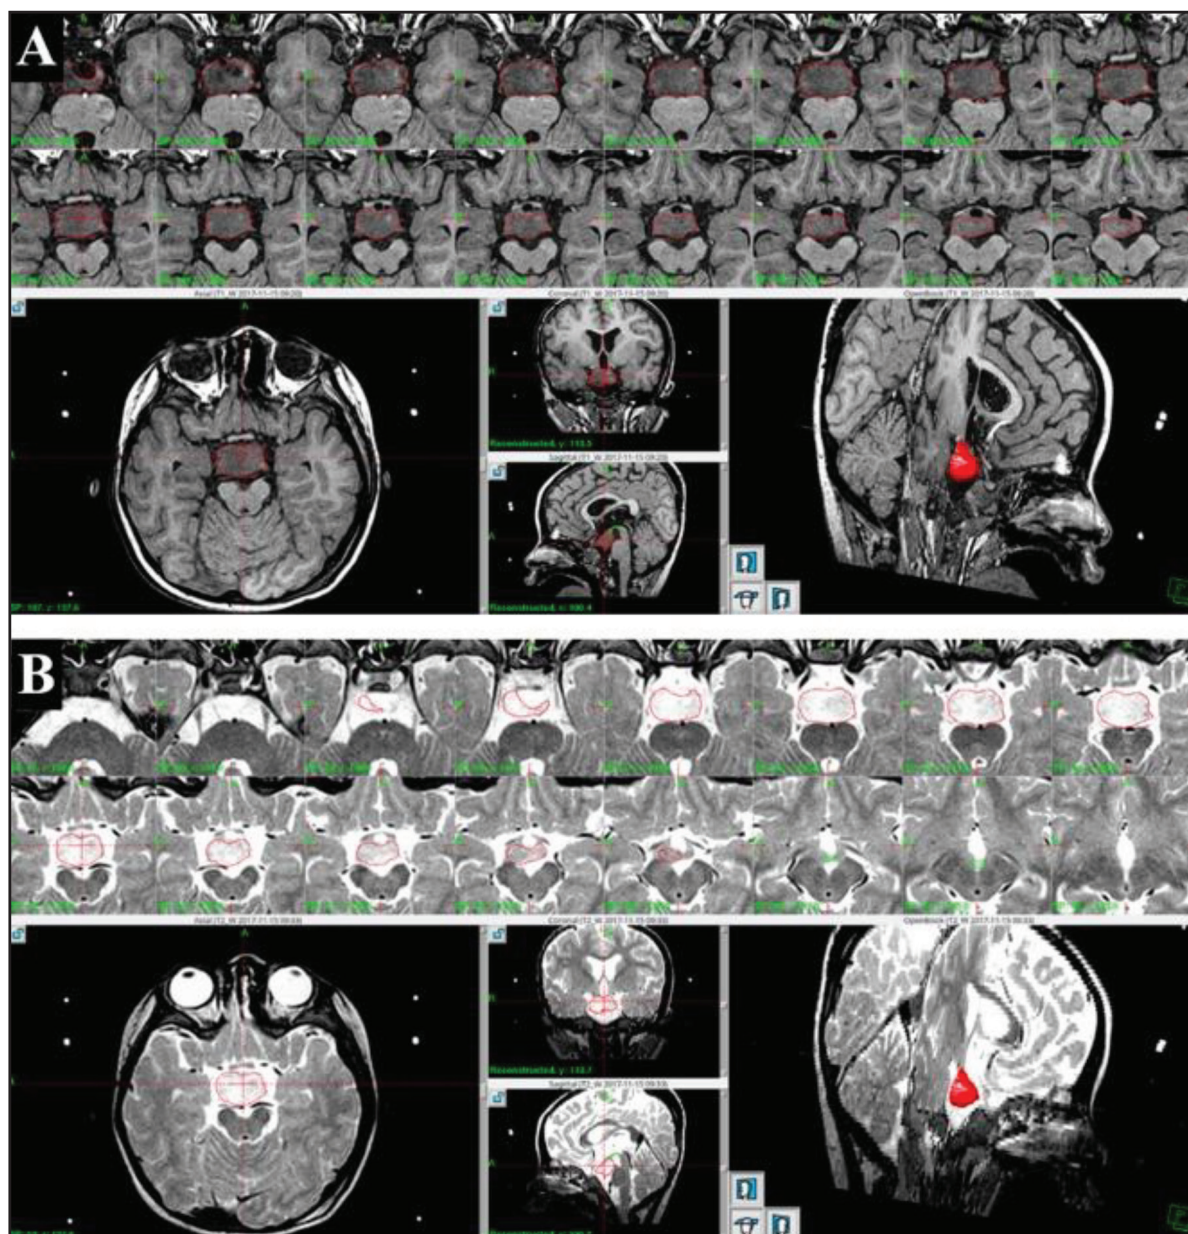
Pre-GKRS MRI of Case 2. Axial T1-weighted (A) and T2-weighted (B) images demonstrating residual HH following prior microsurgical resection. Target volume at the time of GKRS was 6.140 cm³.
